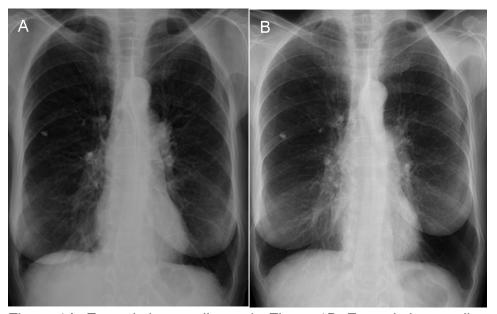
Frontal chest radiograph. Figure 1B: Frontal chest radiograph obtained 2 years prior to Figure 1A.
